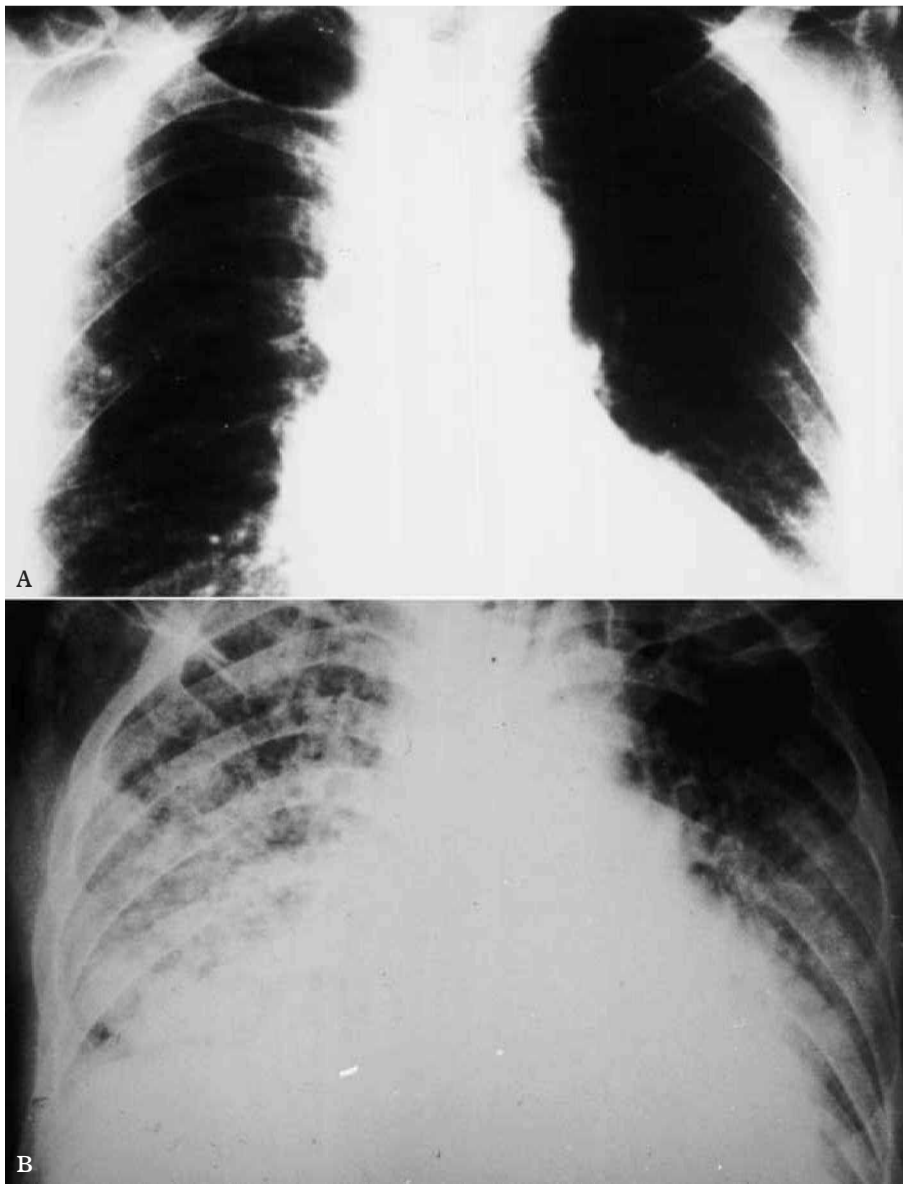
The normal chest X-ray of case 3 at the time of his first admission (a) and the later, abnormal X-ray (b), showing the diffuse bilateral interstitial and alveolar opacities resulting from the *Strongyloides stercoralis* hyper-infection that had developed a week after the patient was re-admitted.
